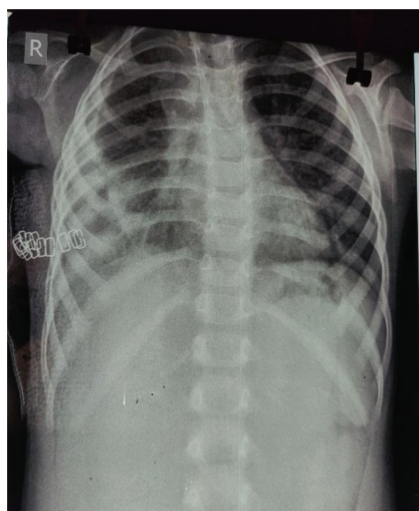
Post operative X-Ray chest right side Empyema
